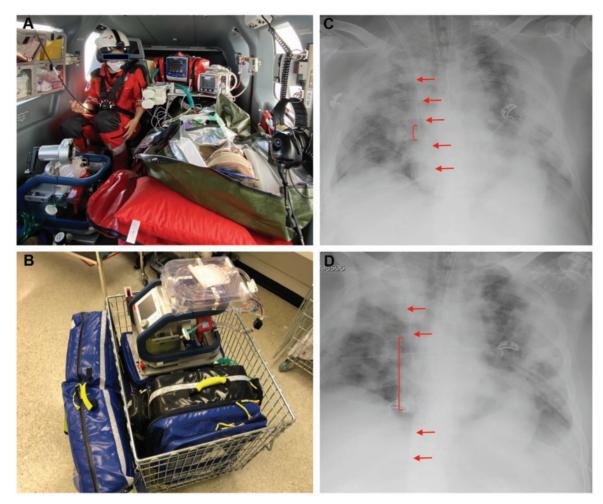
Mobile extracorporeal membrane oxygenation implant equipment. Transportable extracorporeal membrane oxygenation equipment includes 5 transport bags and 1 oxygen cylinder that can be stored compactly (A). Transport of a patient with coronavirus disease 2019 on venovenous extracorporeal membrane oxygenation to our university hospital by helicopter (B). Post-procedural X-ray and blood gas examination are essential to detect cannula displacement during transfer (C and D). ECMO: extracorporeal membrane oxygenation.
